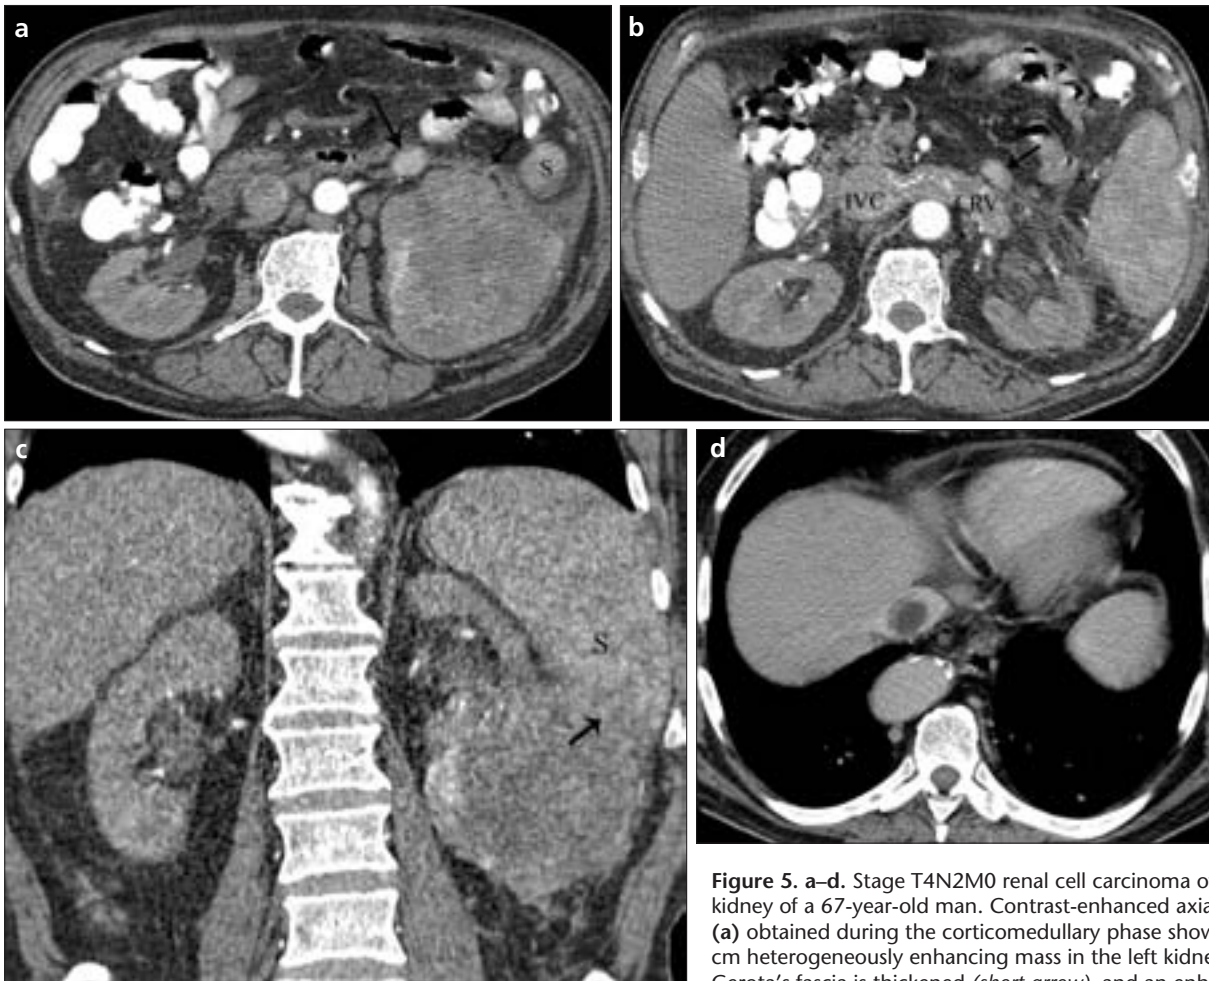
a–d. Stage T4N2M0 renal cell carcinoma of the left kidney of a 67-year-old man. Contrast-enhanced axial CT image (a) obtained during the corticomedullary phase shows a 10 cm heterogeneously enhancing mass in the left kidney. The left Gerota's fascia is thickened (*short arrow*), and an enhancing tumor node (*arrow*) is seen in the anterior pararenal space. Multiple enlarged lymph nodes are present in the left hilar, paraortic, and aortacaval spaces (S: spleen). Axial CT image (b) obtained during the corticomedullary phase shows that the left renal vein (LRV) and inferior vena cava (IVC) are dilated and filled with enhanced thrombus. An enhancing tumor node (*arrow*) is also seen. Coronal CT image (c) shows the absence of the tissue plane (*arrow*) between the mass and the spleen (S). At surgery, tumor was observed to have invaded the spleen. Axial CT image (d) obtained during the nephrographic phase shows a tumor thrombus at the supradiaphragmatic inferior vena cava.
